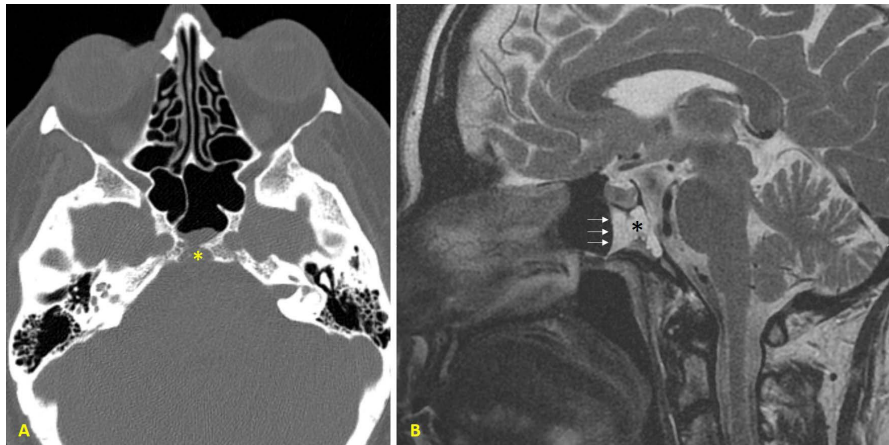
(A): Axial CT scan image shows a lytic lesion on the cranial aspect of clivus, with well-defined and partially sclerosed borders. (B): Sagittal T2 enhanced MR image shows a hyperintense lesion in clivus protruding into the pontine cisterna and the sphenoidal sinus (asterisks). An air-fluid level (arrows) is observed in the sphenoidal sinus.
